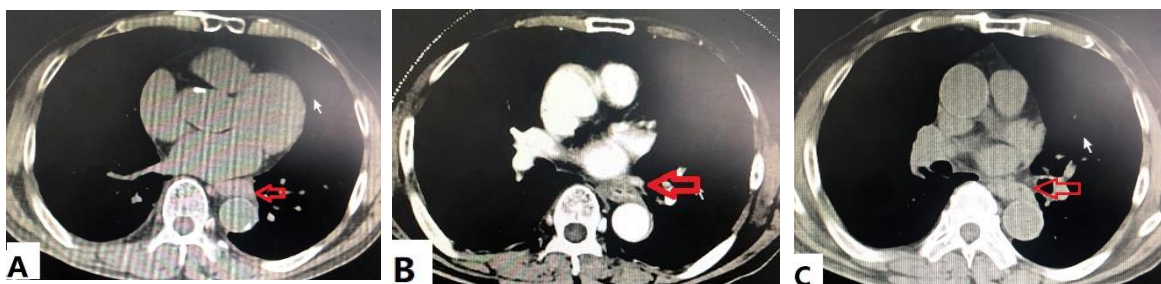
Computed tomography showed the effects of esophageal carcinoma after
